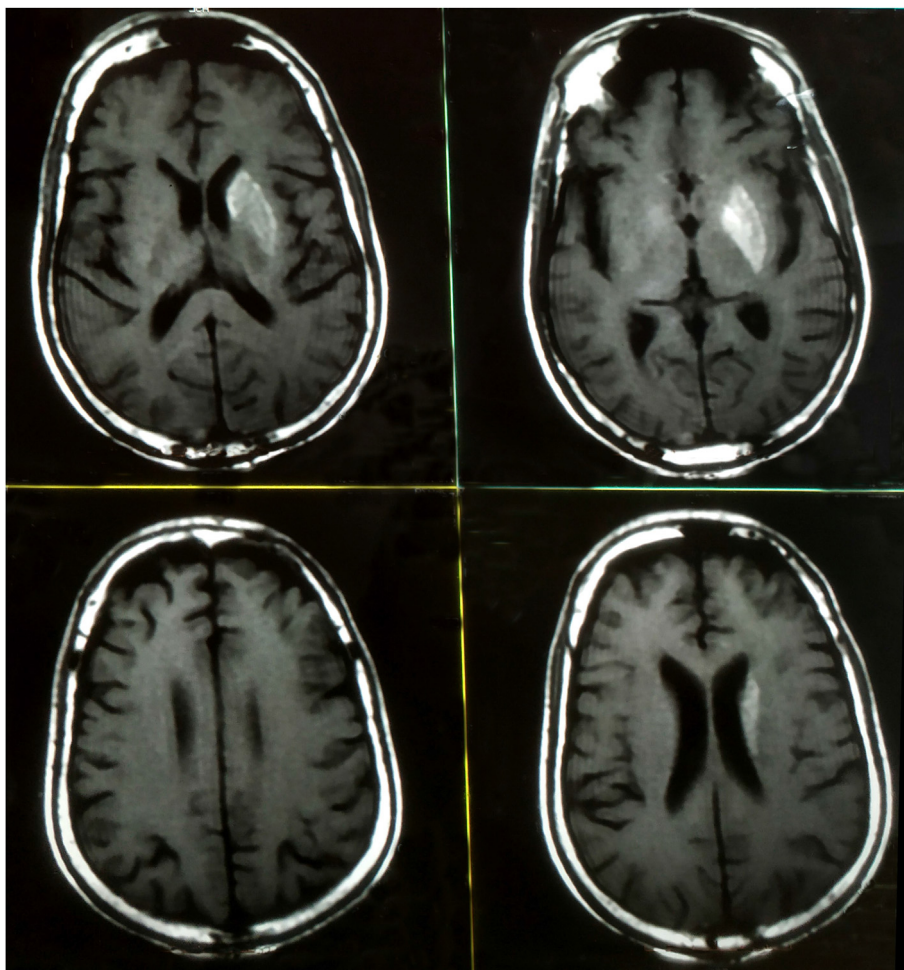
MRI of the brain revealing increased signal intensity on T1-weighted imaging in the left caudate, putamen and globus pallidus, suggestive of striatopathy.
